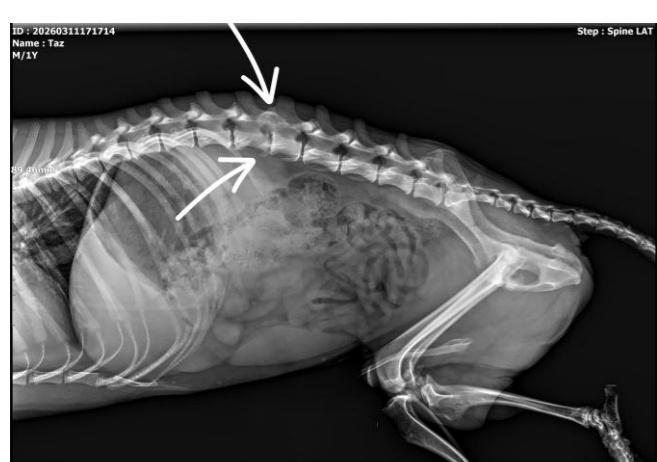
Latero-lateral digital radiograph, view of the lumbar, sacral and coccygeal segments of the spine showing the lumbar stenosis
